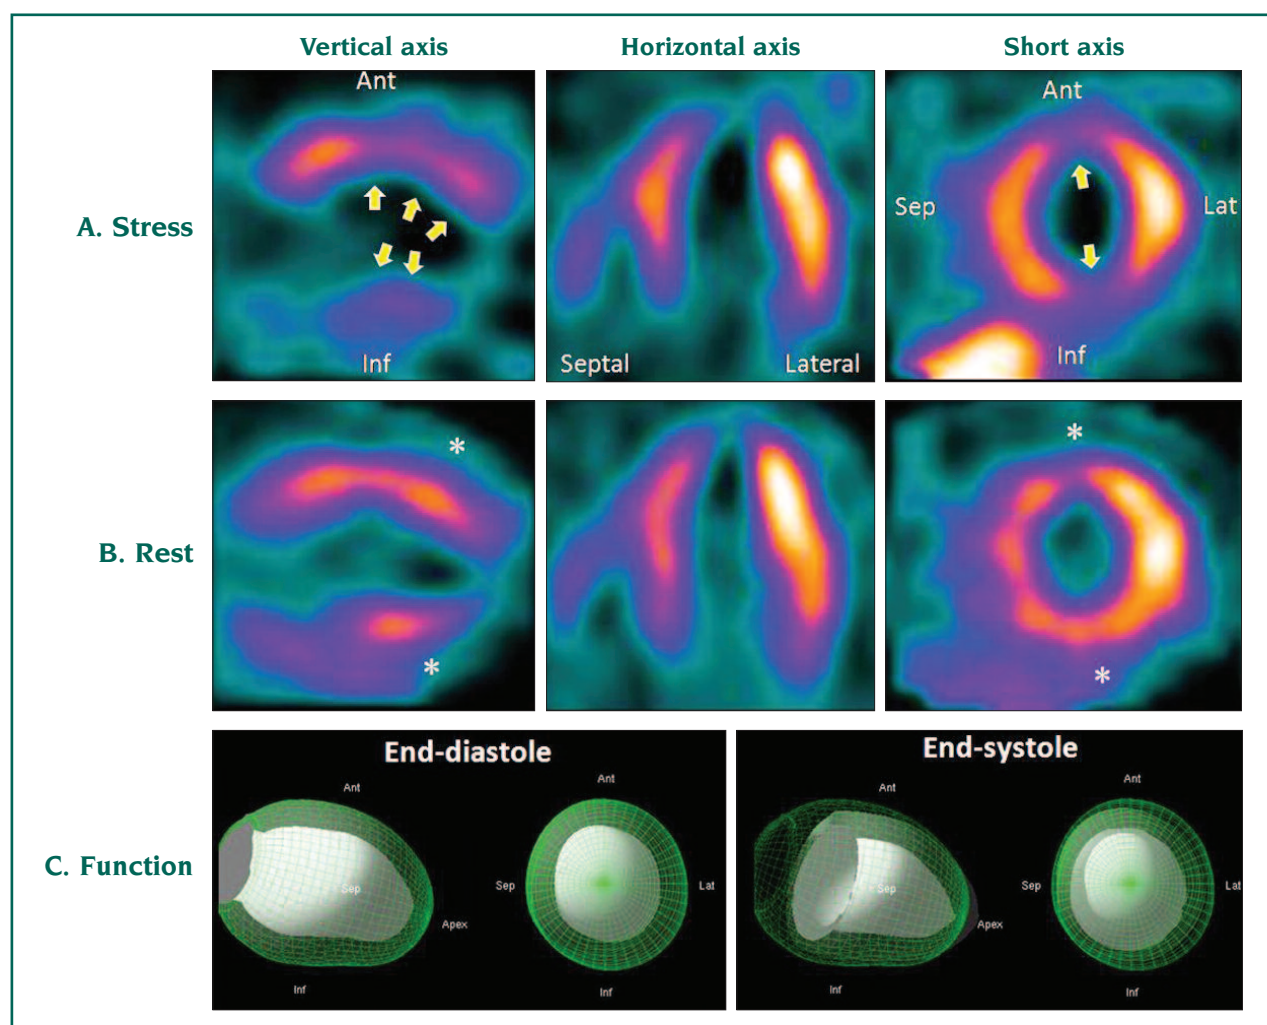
Exercise and rest Tc-99m tetrofosmin SPECT images in a patient with 3-vessel CAD and severe LV systolic dysfunction.
